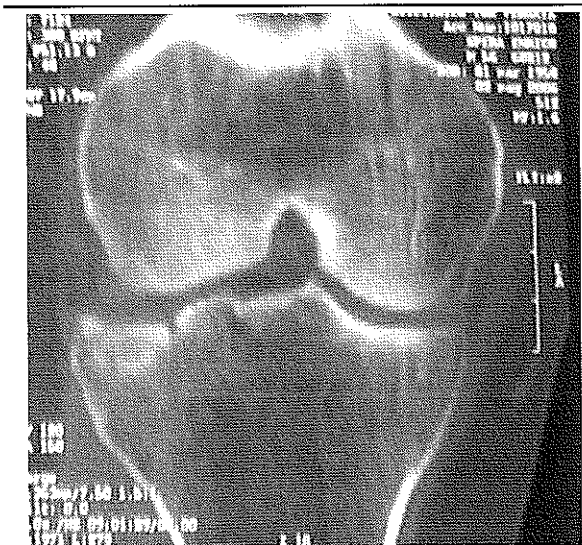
Computed tomography appearance of knee fracture.
